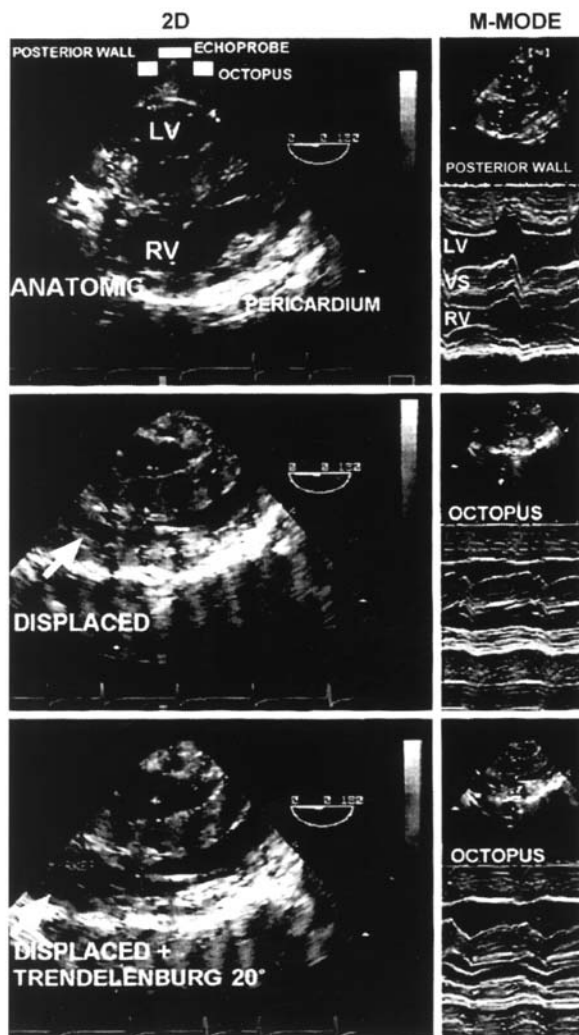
Echographic cross-sectional areas (left panels) and M-mode images (right panels) obtained during 90 anterior displacement (DISPLACED) and subsequent head-down positioning (+ TRENDLENBURG). VS = ventricular septum; RV = right ventricle; LV = left ventricle. The ultrasound probe was positioned between two Octopus tentacles and aligned to the posterior wall (ANATOMIC). Note the severe deformation of the RV on cardiac retraction (arrows, DISPLACED) and the partial recovery of RV cross-sectional area after the Trendelenburg maneuver. *Reproduced from reference 14 with permission.*
